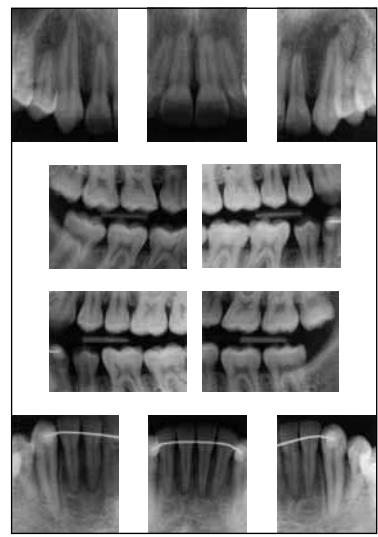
Final periapical radiographs of anterior superior and inferior teeth and left and right bitewings radiographs.
